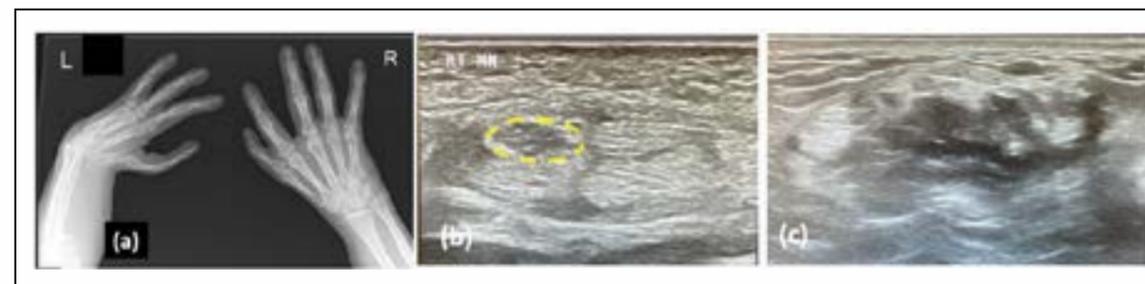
(a) This patient with bilateral radial dysplasia presented with severe median nerve compression in his right hand. Note the scaphoid hypoplasia on the right wrist indicating a mild radial dysplasia with thumb hypoplasia. (b) Ultrasound images showed an enlarged median nerve proximal to the carpal tunnel (yellow dotted line). Such imaging is helpful when planning surgery as the position of the nerve may be abnormal and (c) The left wrist was also scanned but no median nerve could be seen convincingly.
